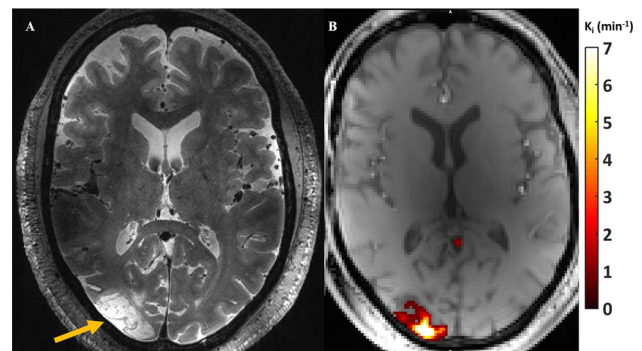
T2-weighted slice with the stroke lesion indicated with a yellow arrow (A) and corresponding slice of a slow image with an overlay of the Ki map (leakage in the arteries is removed) (B). Elevated leakage can be noted in the stroke lesion.
